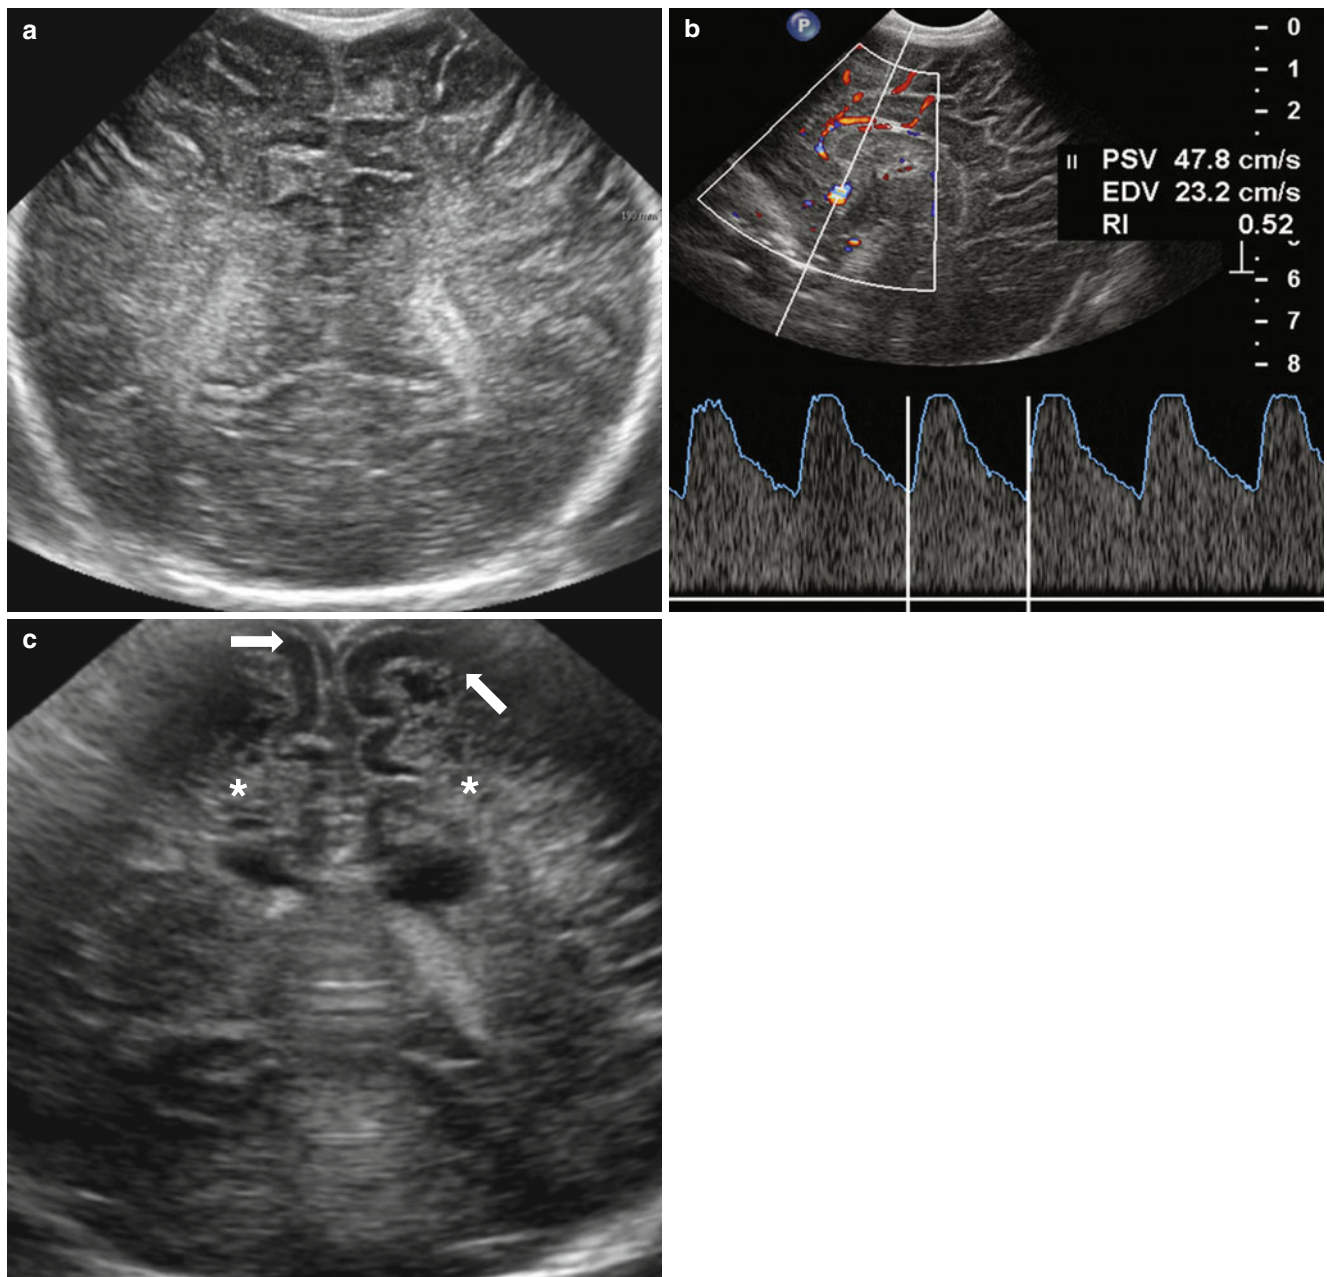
Diffuse hypoxic-ischemic encephalopathy in the term neonate at 39+4 weeks gestational age. (a) Coronal scan shows diffuse, heterogeneous echogenicities of brain parenchyma with obliteration of ventricles and cortical sulci. (b) Color Doppler image on anterior cerebral artery shows decreased resistive index (0.52). (c) Follow-up
